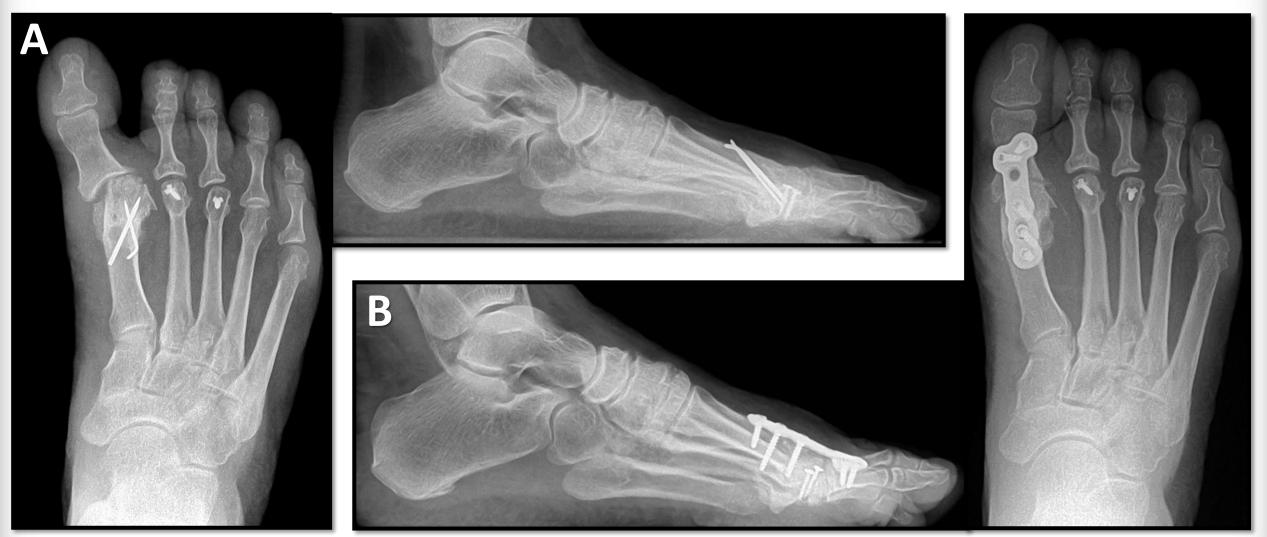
A) Pre-operative AP and Lateral radiographs of patient with hallux varus after bunionectomy. B) Post-operative AP and Lateral radiographs.
